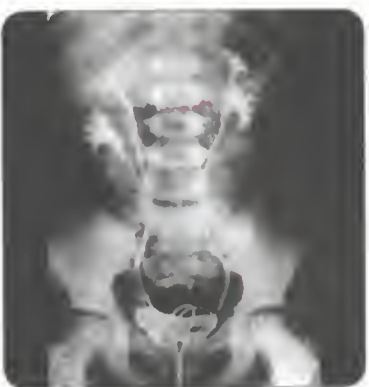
X-ray showing bilateral duplex system
